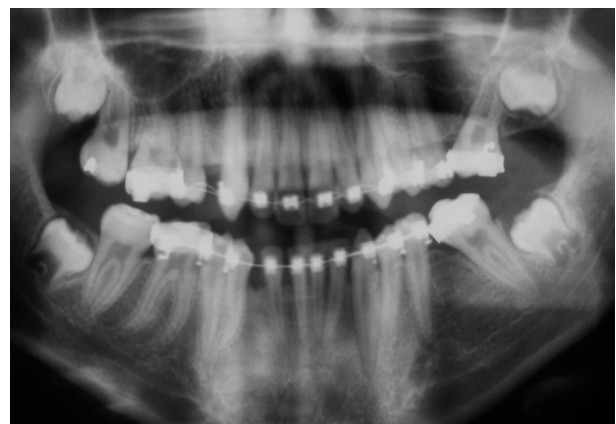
Postoperative panoramic dental X-ray. Control at 2 years.
